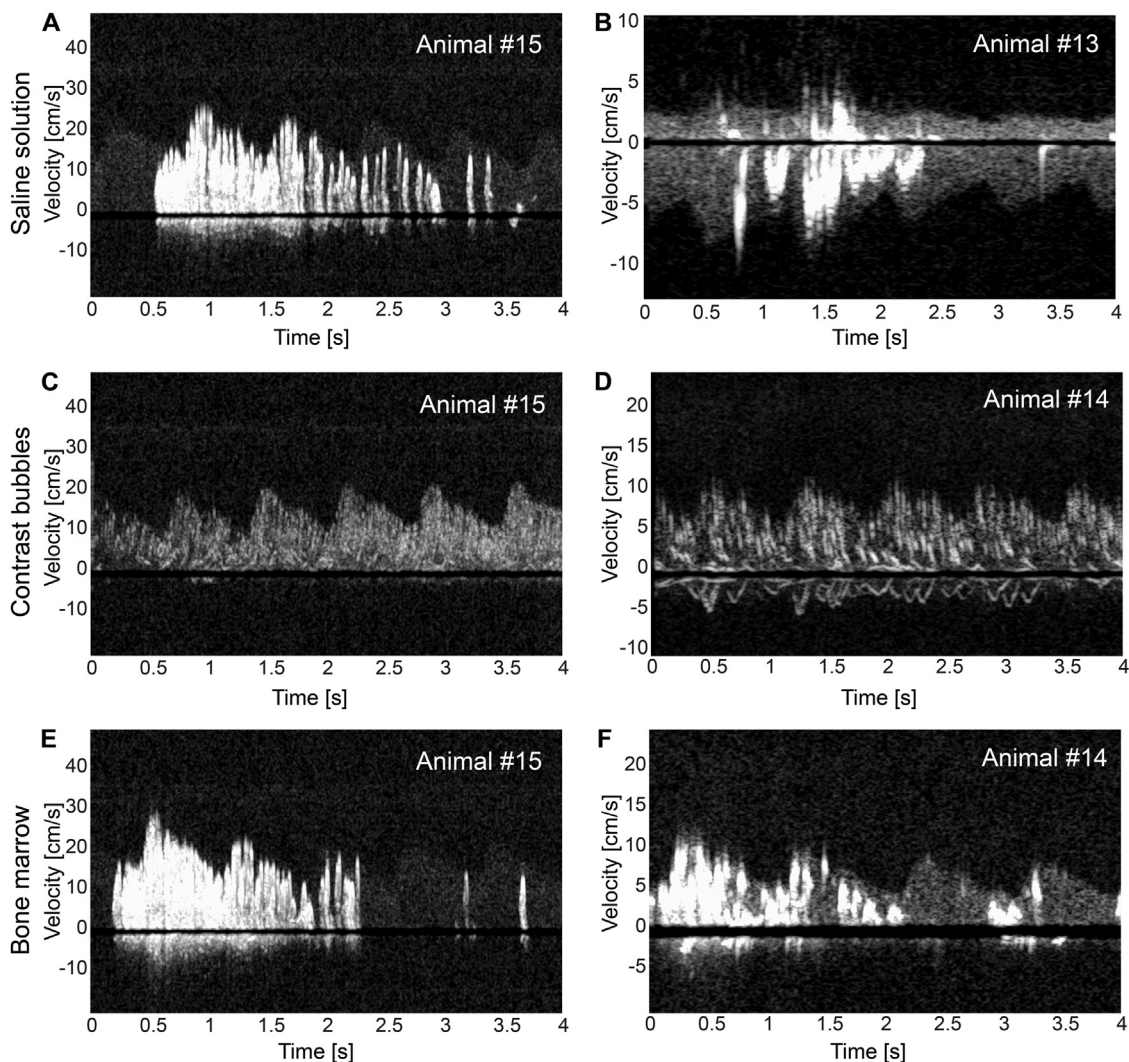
Examples of HITS produced by injection of (A, B) agitated saline solution, (C, D) ultrasound contrast, and (E, F) bone marrow.
